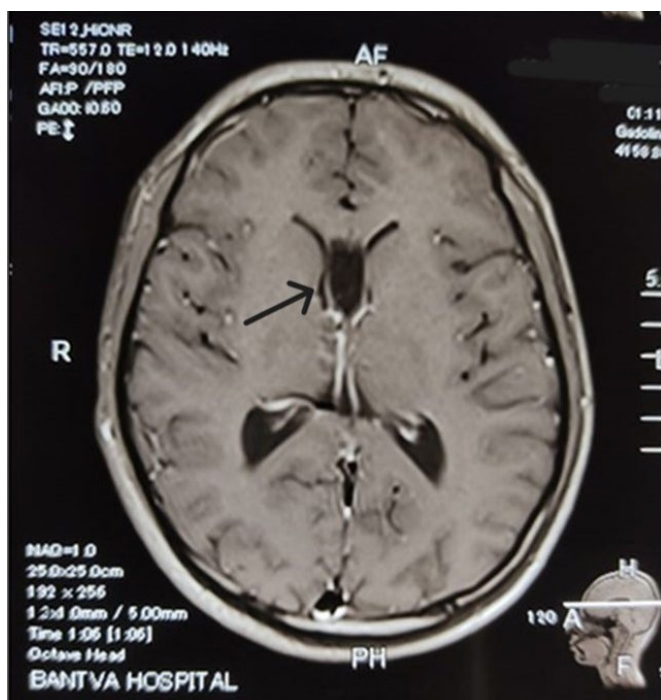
T1 Weighted MRI in axial view showing CSP cyst (arrow).
